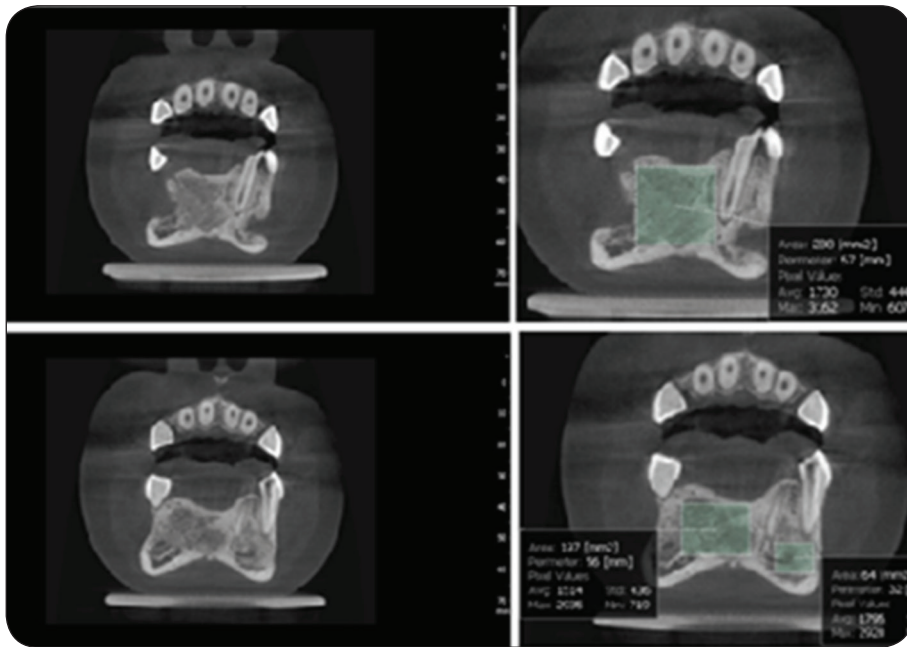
Postoperative follow up CBCT with measurement of Bone Density at follow up 3,6 For GPI, II, III
